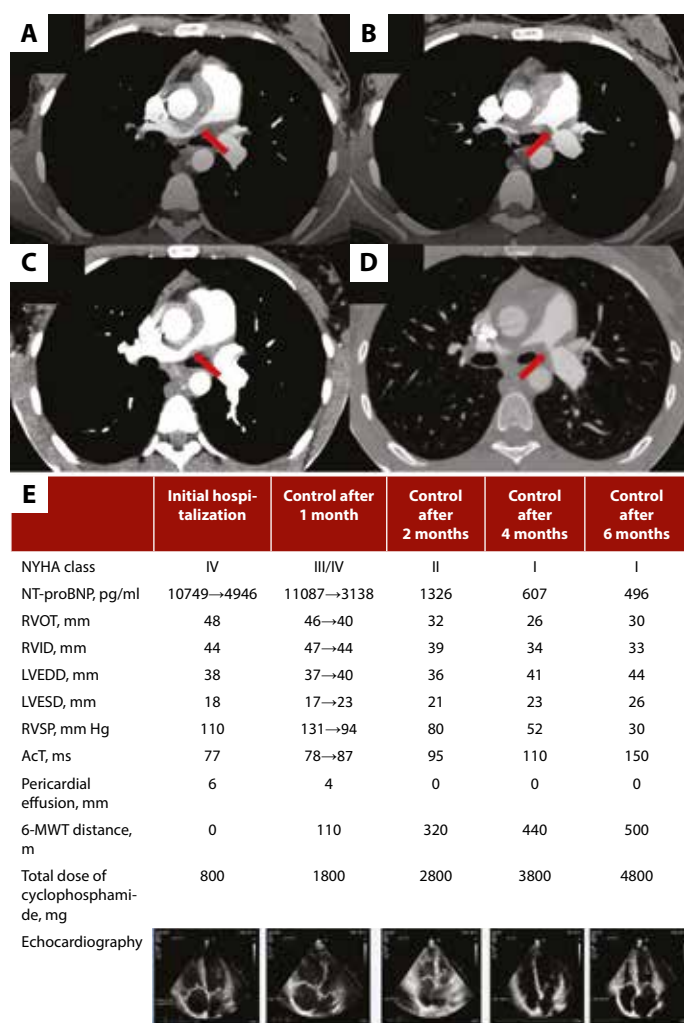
Contrast-enhanced computed tomography (CT). The initial angio-CT scan showed critical stenosis in pulmonary arteries, causing 99% narrowing of the lumen of the right pulmonary artery (RPA) (A, red arrow) and 95% of the left pulmonary artery (LPA) (B, red arrow). Control angio-CT scan after 6 months showed substantial regression of stenosis in both RPA (C, red arrow) and LPA (D, red arrow). E. Clinical, laboratory, and echocardiography parameters according to the total dose of cyclophosphamide in subsequent hospitalizations
